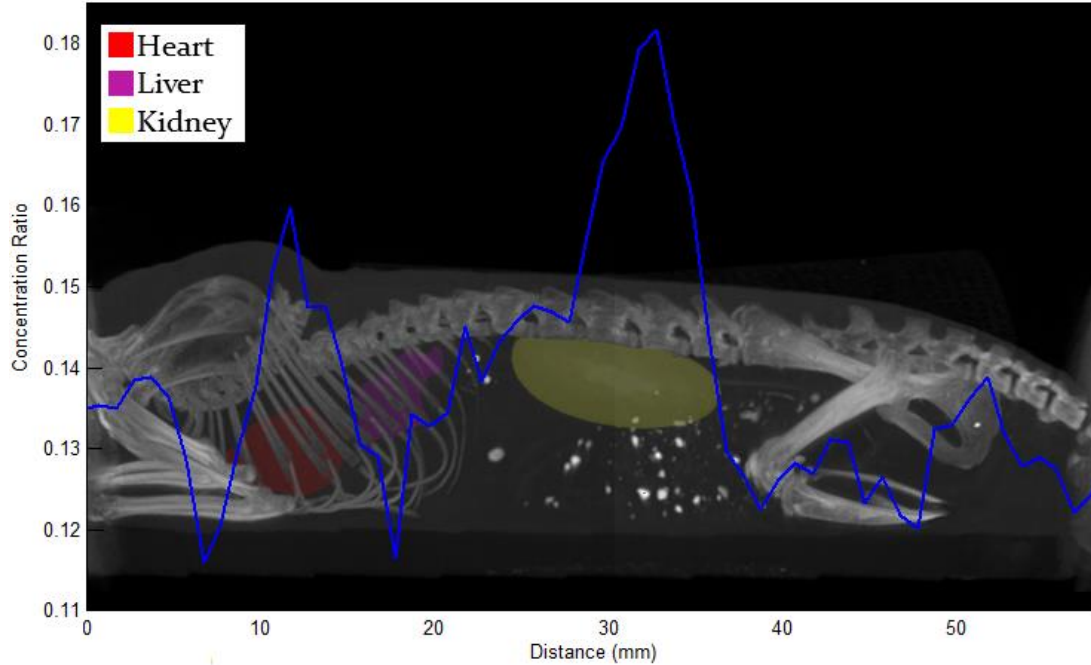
Fluorescent signal vs position graph overlaid on a CT sagittal projection with color marked organs. 10 minute perfusion; 1mm/step, 20 s/step, 90 mm total scan distance
